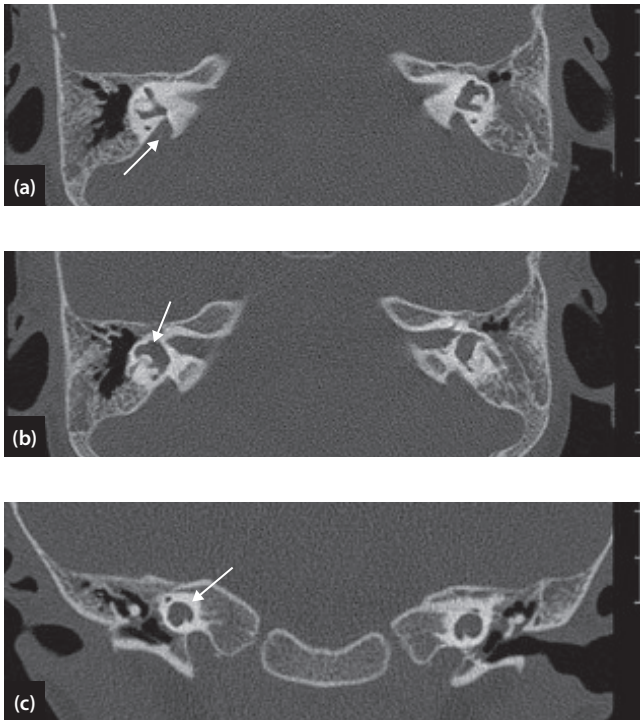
Typical appearances of a Mondini deformity in a child with bilateral severe sensorineural deafness. Axial high resolution CT scan through (a) dilated vestibular aqueducts and (b) a more inferior slice that shows bilateral dysplastic vestibules. (c) Coronal image through the abnormal cochlea showing typical Mondini abnormality with incomplete formation of the apical and middle turns of the cochlea. Images kindly supplied by D Saunders, Consultant Neuroradiologist, Great Ormond Street Hospital, London, UK.
